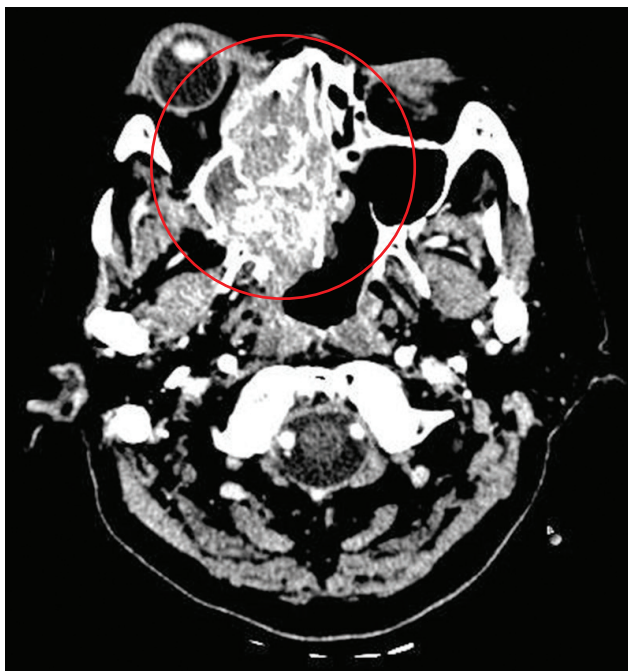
Head CT scan (axial view, brain window) shows a large hyperdense mass (red circle) arising from the right ethmoid sinus, invading the right maxillary sinus and sphenoid sinus, and extending to the right orbit.
